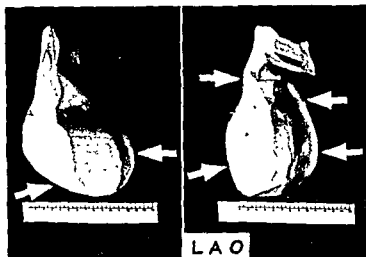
Young male. Rheumatic aortic regurgitation. Compensation. Roentgenologic, volumetric reconstruction. Ant view. moderate enlargement of lt. ventricle caudad and to lt (lt arrow) Rt ventricle (rt lower arrow) Lt ant obl view prominence of lt ventricle dorsad (lt lower arrow) Rt ventricle (rt lower arrow) Cranial portion ascending aorta (rt upper arrow) Lt atrium (lt upper arrow) Courtesy Prof Dr G G Palmieri, Bologna, Italy
